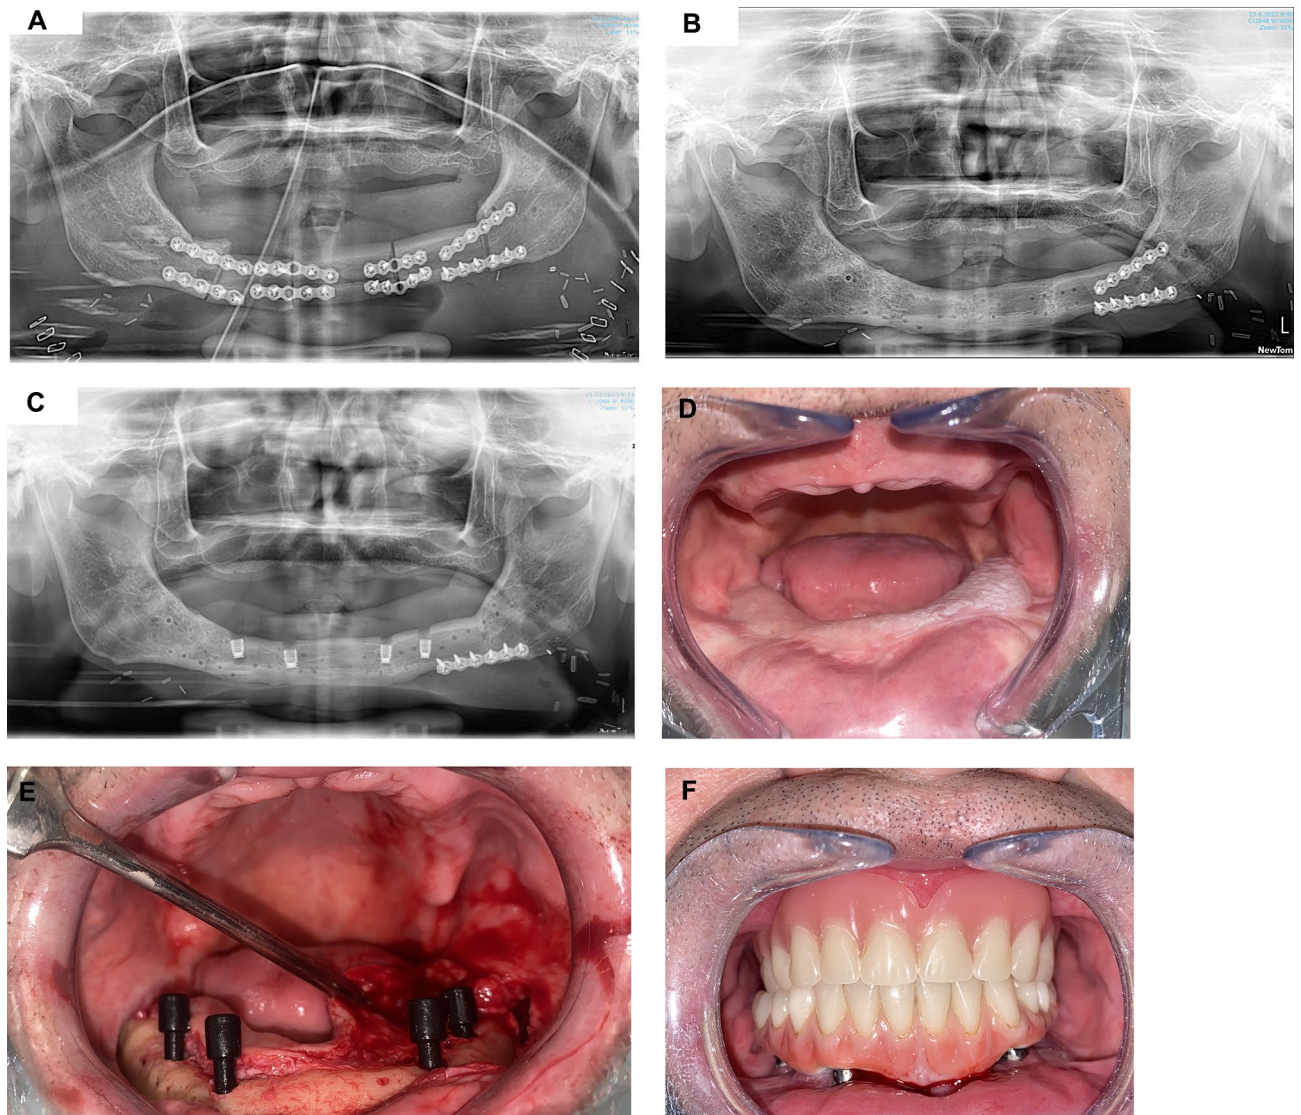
Radiographs and clinical photographs of a mandibular reconstruction. (A–C) panoramic radiographs taken after free flap reconstruction of the mandible, removal of titanium plates, and placing four dental implants, respectively. (D, F) intraoral photographs taken after free flap healing, implant uncovering, and prosthesis delivery, respectively.
